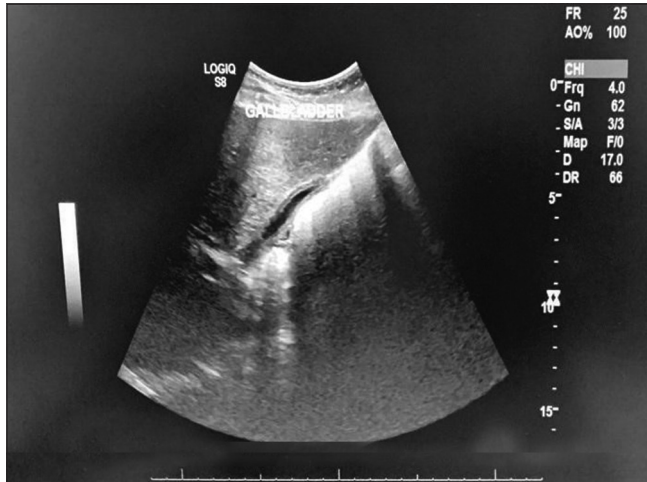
Abdominal Ultrasound shows contracted gall bladder without presence of stones.
